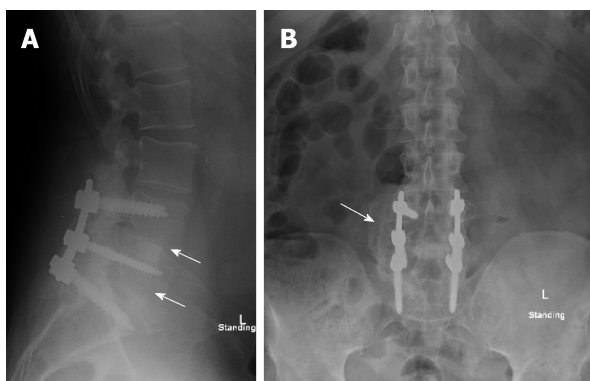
One-year post-operative radiographs showed interbody fusion and posterolateral fusion mass (arrows). A: Anteroposterior; B: Lateral.
